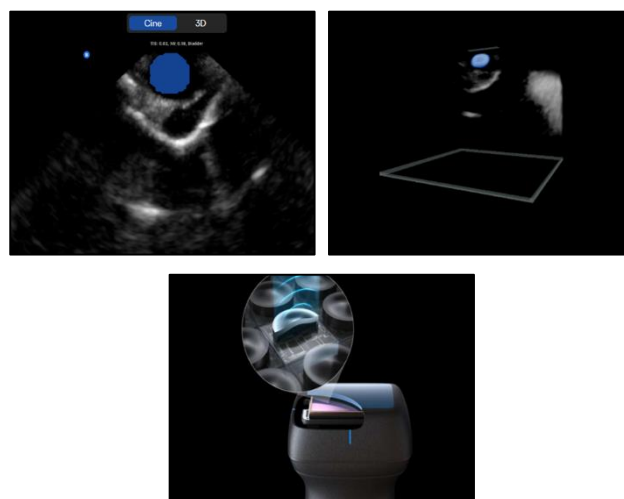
Large Intra-Orbital Abscess with delineation and 3D configuration using TGC extended to extraconal space using Butterfly IQ+ Handheld Ultrasound.
